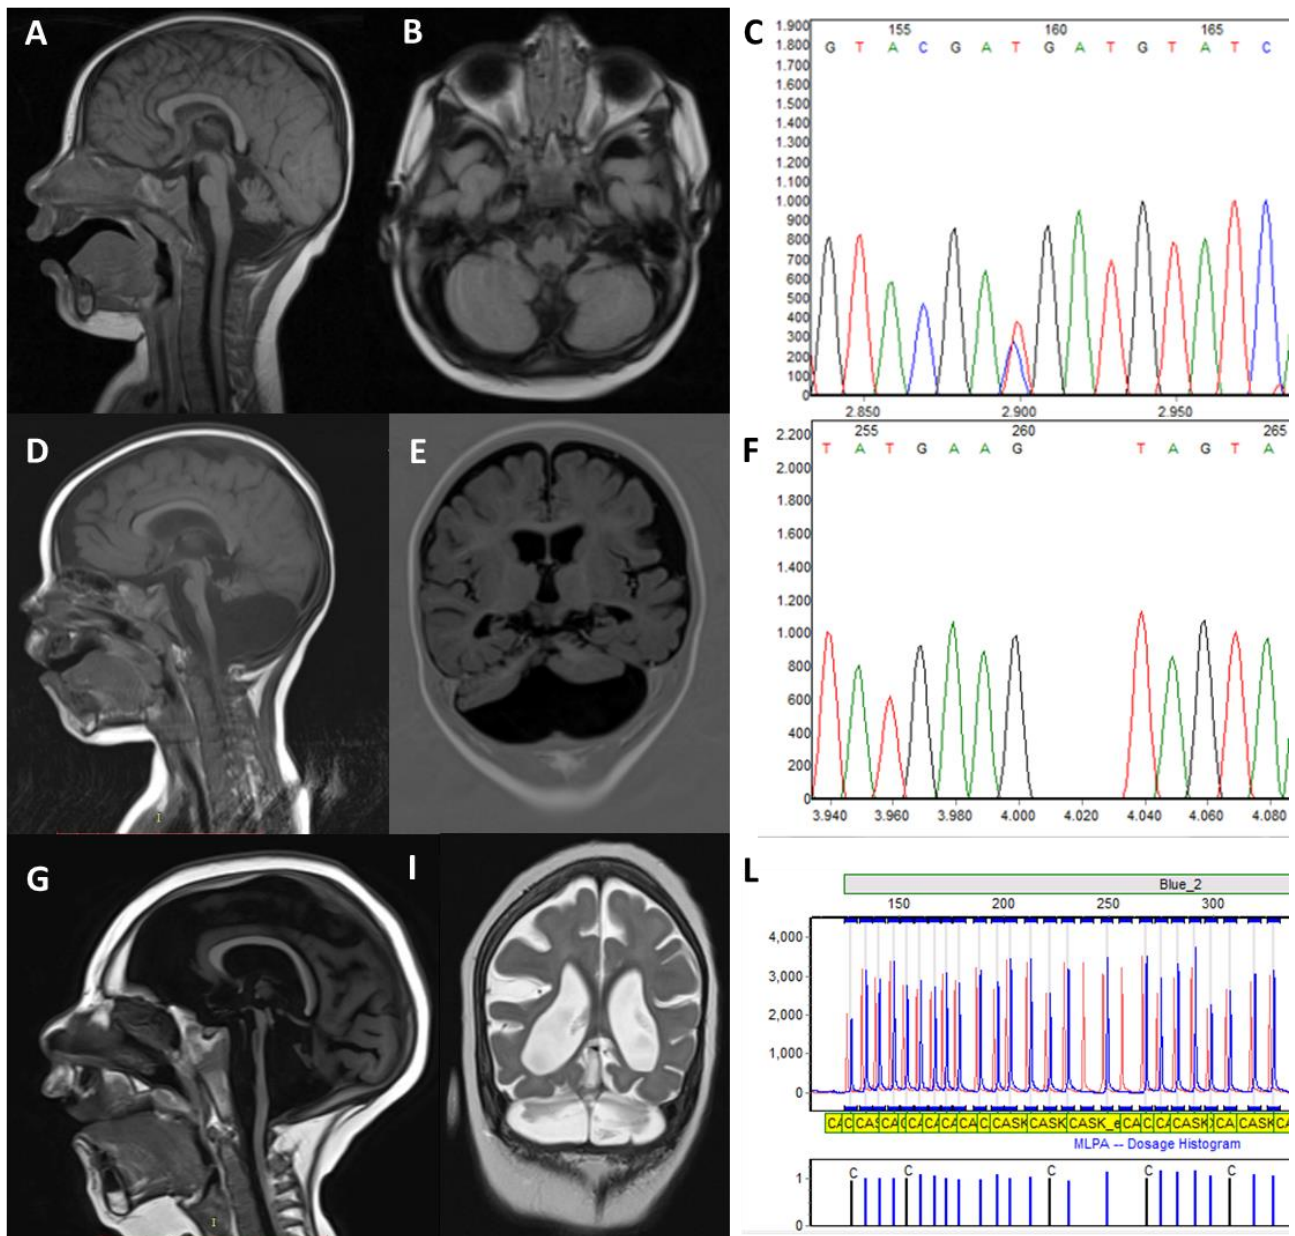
Male CASK probands. MRI sagittal (A) and axial (B) scans and electropherogram (C) of proband CCM195; sagittal (D) and coronal (E) sections and electropherograms (F) of proband CCM510; sagittal (G) and coronal (H) scans and MLPA graphic analysis (I) of proband CCM395.
